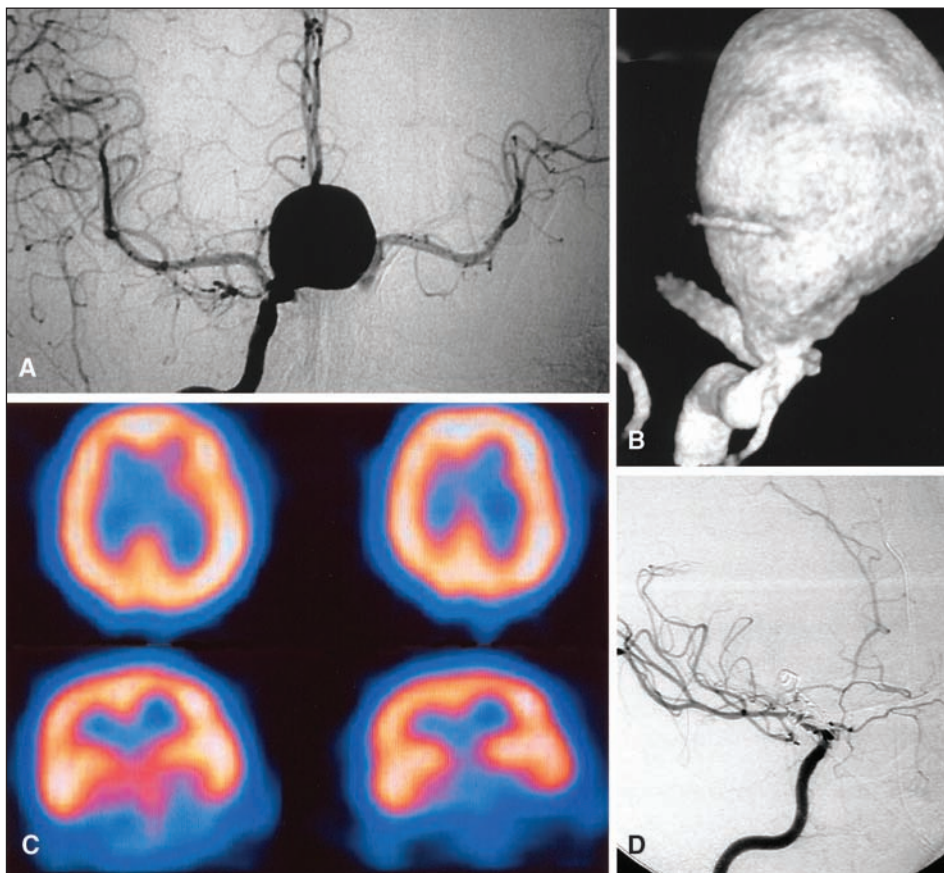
Case 14. Preoperative cerebral angiogram of the right internal carotid artery (A). 3-D angiogram (B). SPECT during the occlusion test showing symmetry of the cerebral perfusion (C). Postoperative cerebral angiogram (D).
